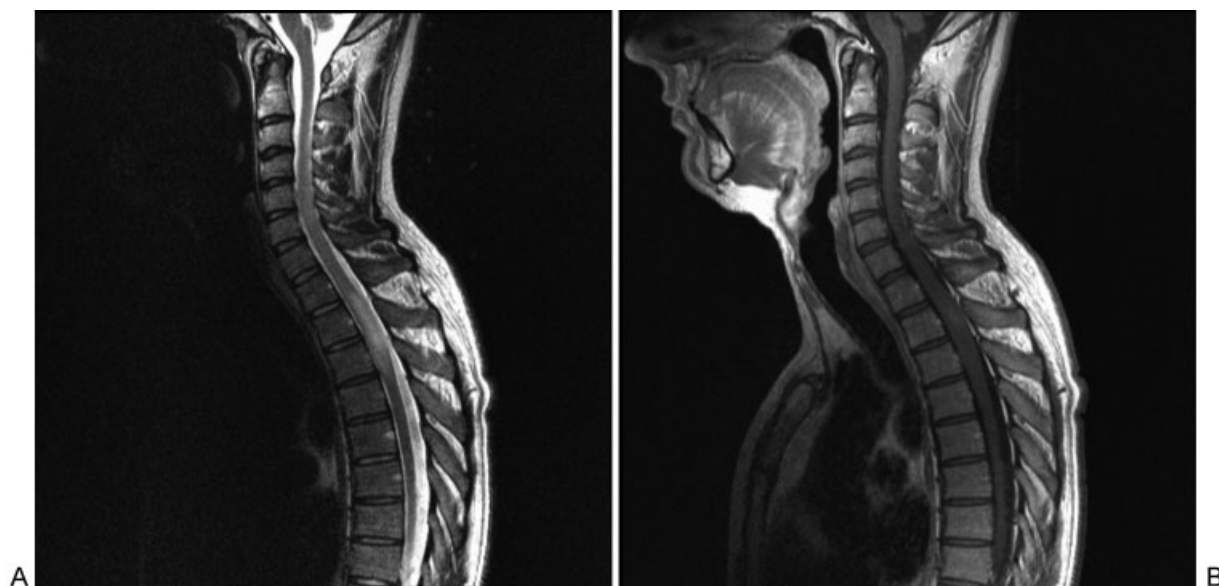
(A) Sagittal T2-weighted and (B) sagittal T1-weighted plus gadopentetate dimeglumine magnetic resonance images demonstrating alterations of the morphology and signal intensity of the spinal cord from T2 to T3 and a slight gadolinium enhancement in this area.
